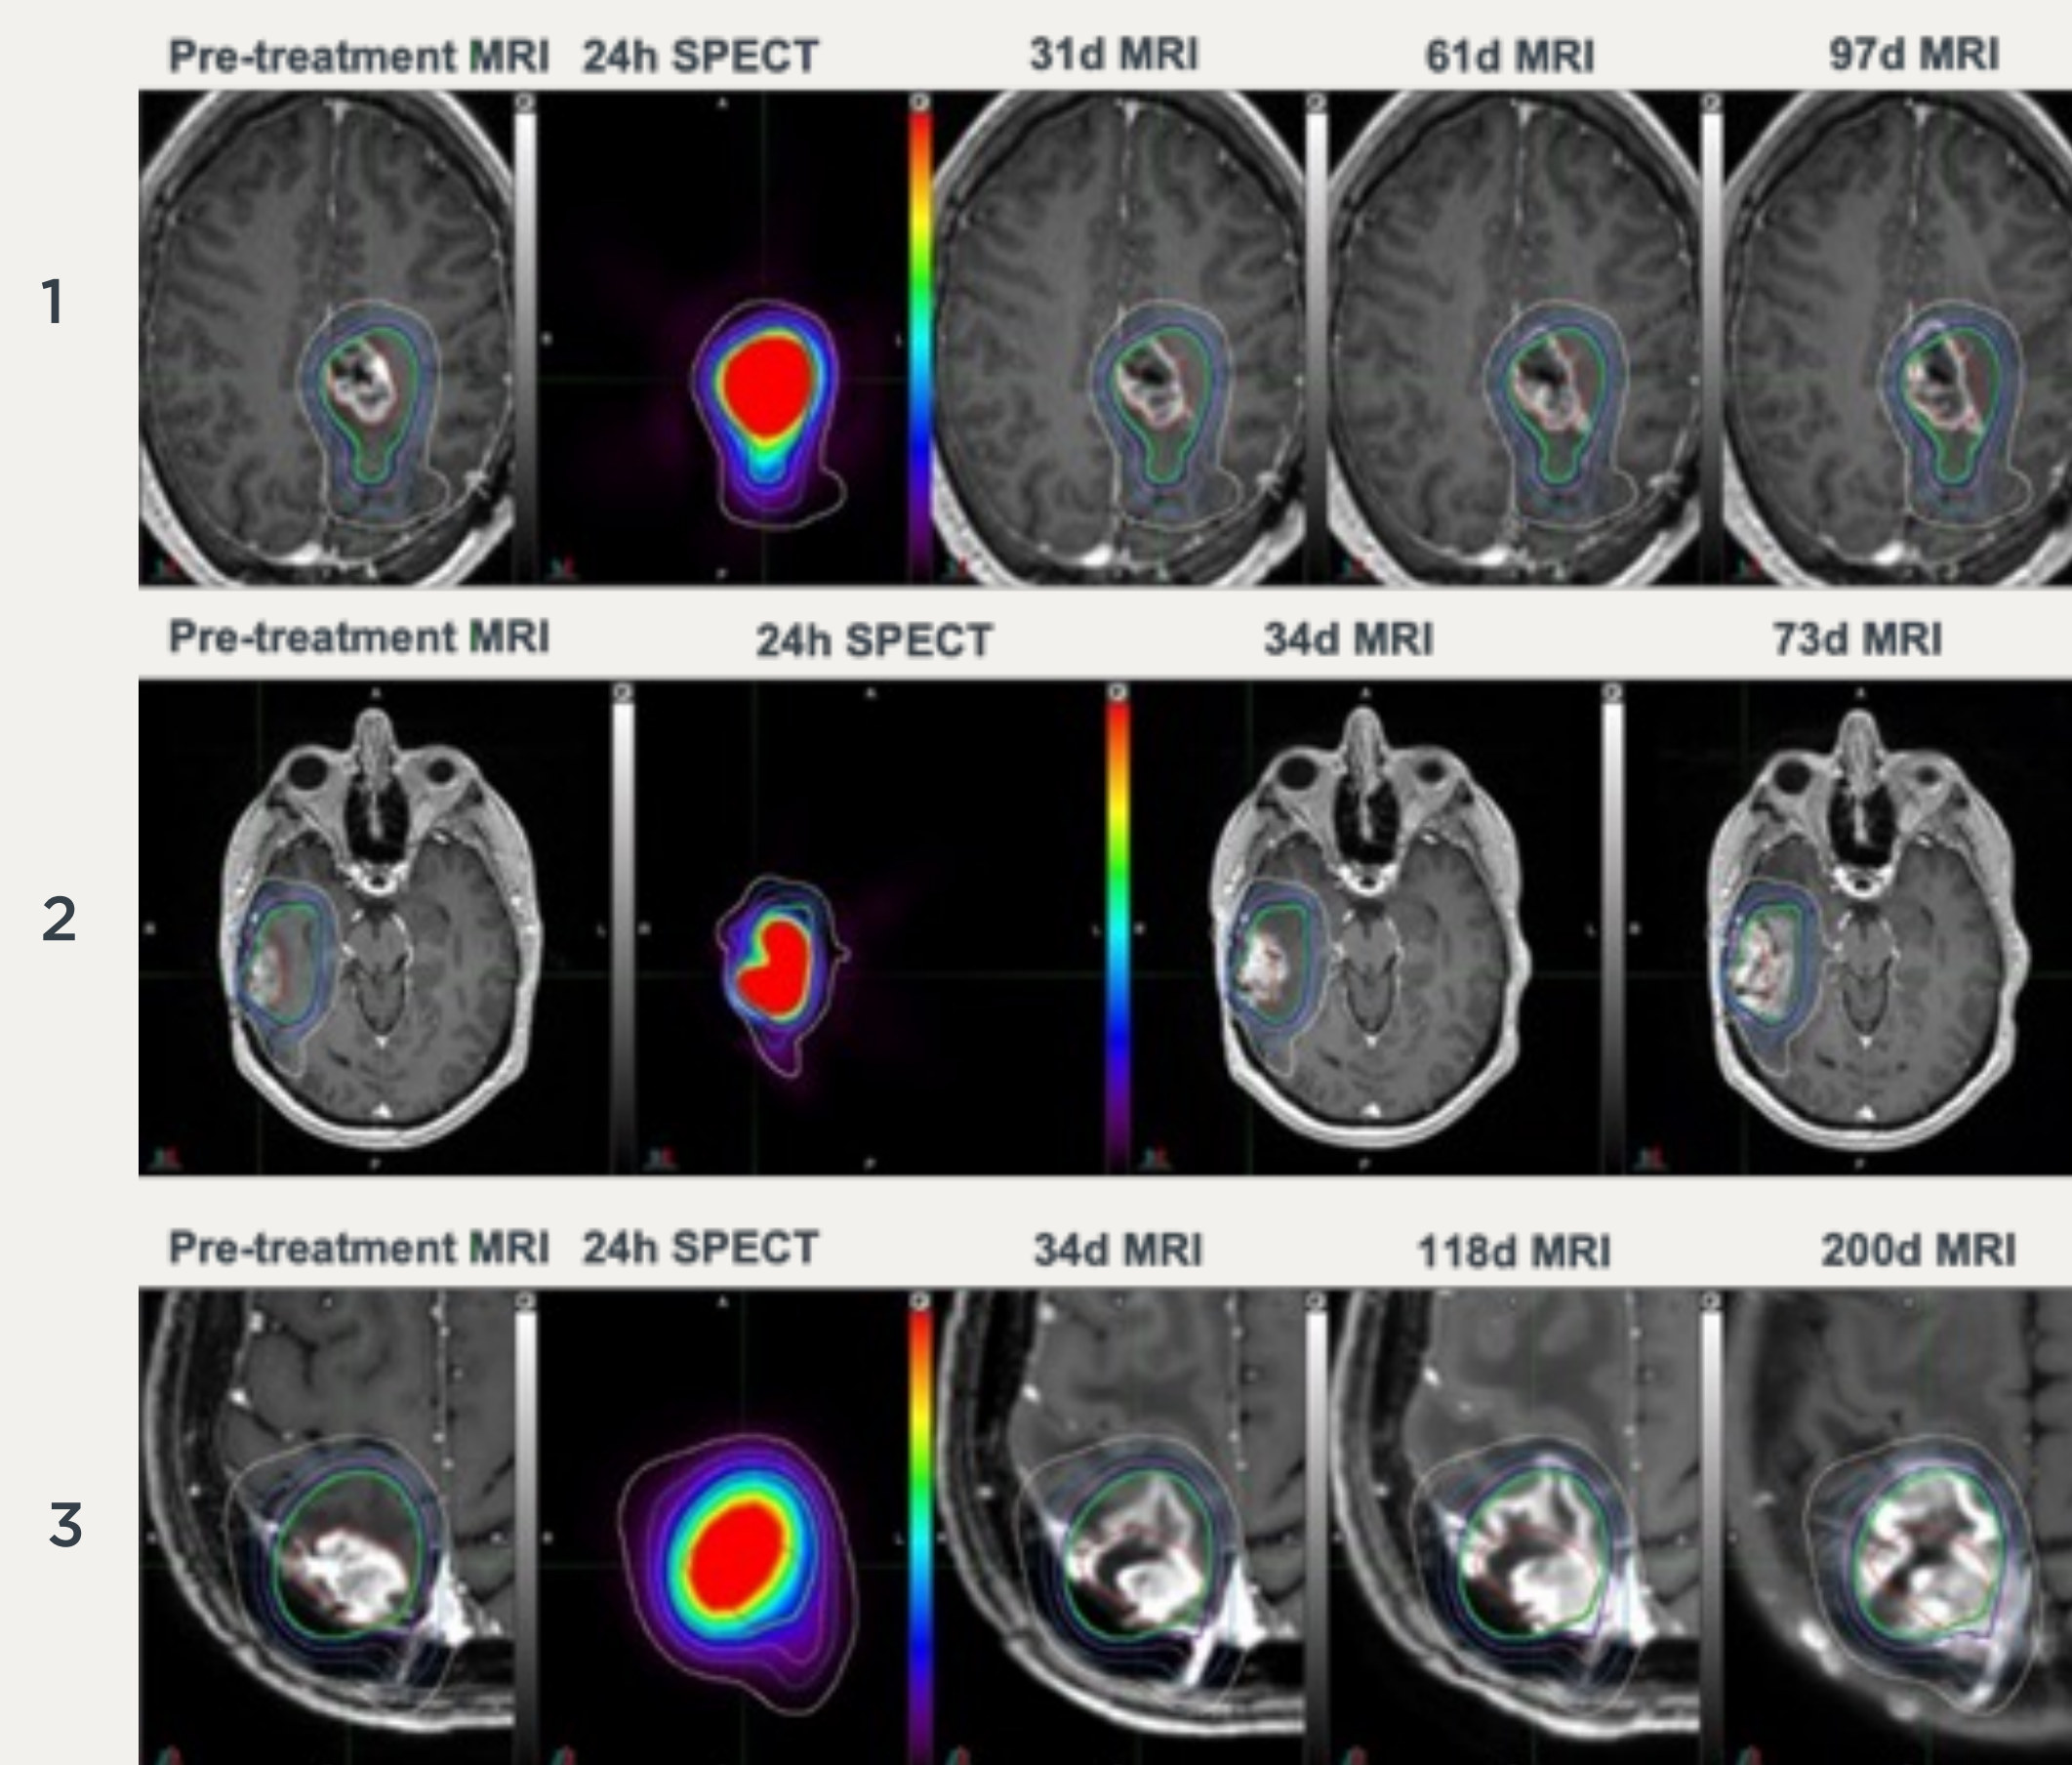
Pretreatment MRI, 24-hr post-treatment SPECT, and post-treatment MRI. (1) Phase 1 patient, cohort 4. (2) Phase 1 patient, cohort 5. (3) Phase 1 patient, cohort 6. Overall survival ranged from 750-1200 days.
